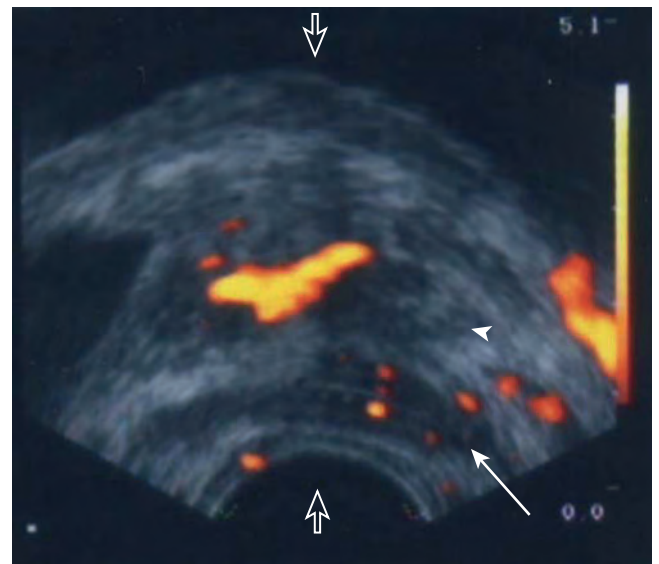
Transrectal ultrasound examination demonstrates hypoechoic tumor in the left base (*arrowhead*) with likely extension into the ipsilateral seminal vesicle (*arrow*). (Courtesy Dr. Katsuto Shinohara.)
